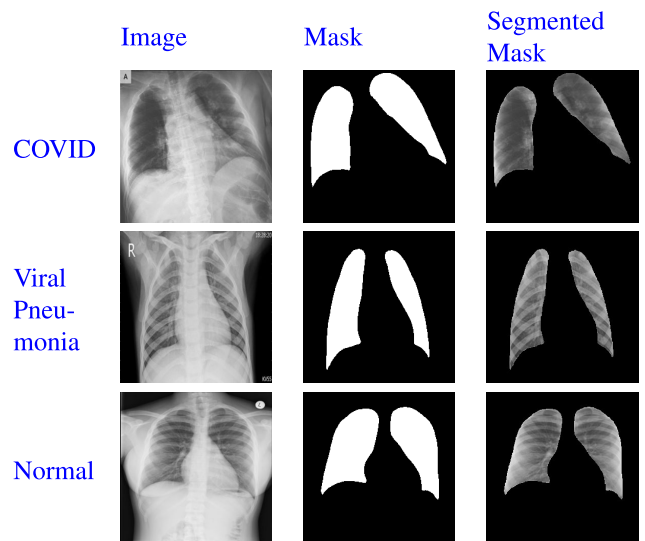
Chest X-rays, Lung mask and segmented mask for COVID-19, viral pneumonia, and healthy lung image.
